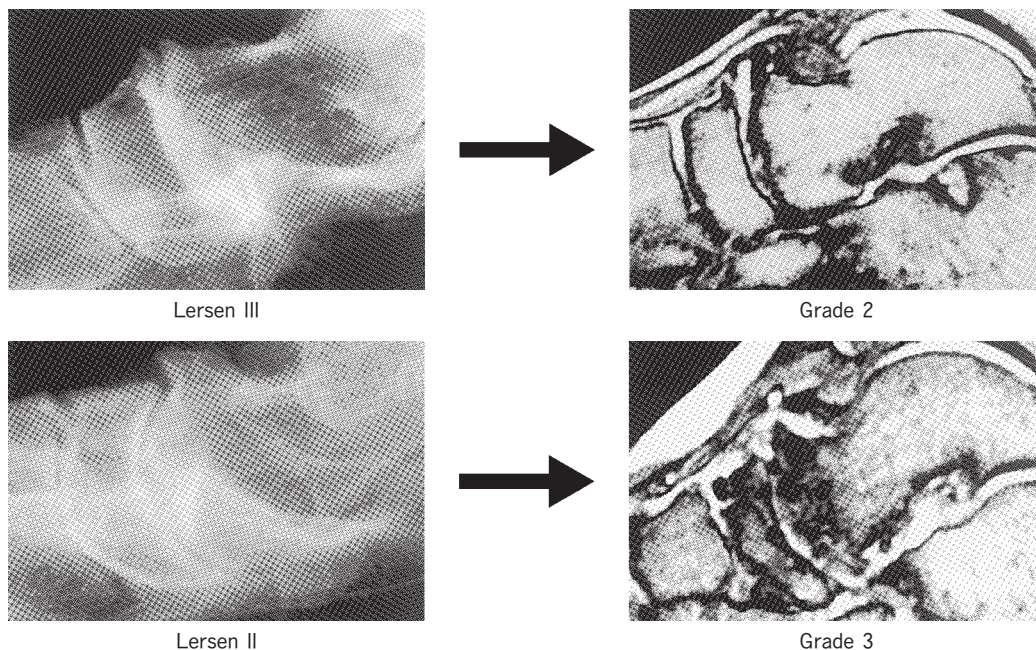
MRI visualized the talonavicular joint more precisely than plain X-ray.
